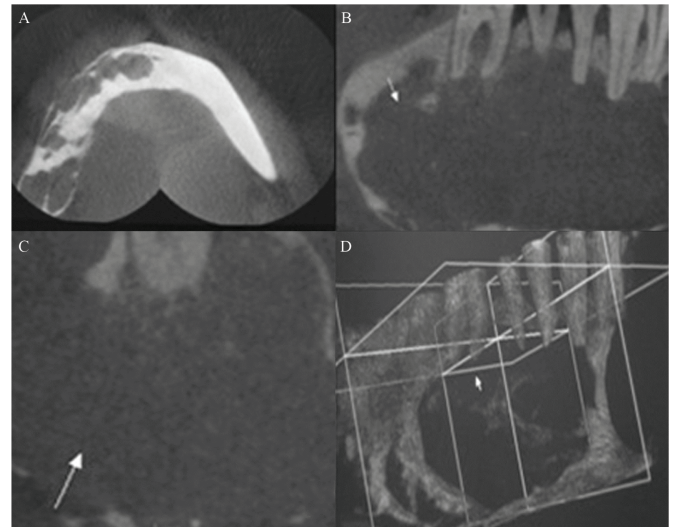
Radiographic image in three-dimensional (3D) sections. A: transverse section; B: coronal section; C: sagittal section; D: 3D section.
